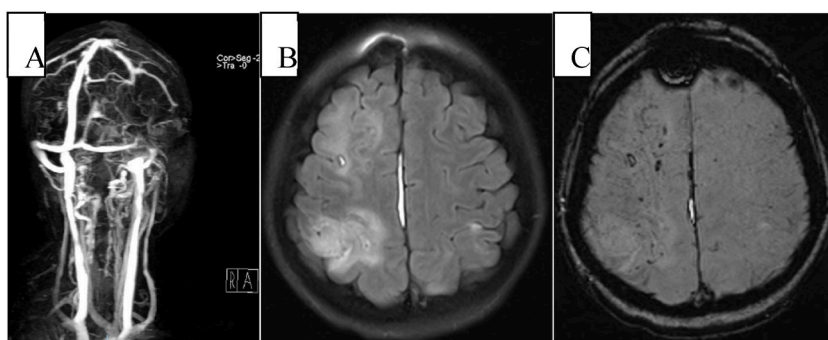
MRV, MRI, and SWI findings at 17days after the surgery.
